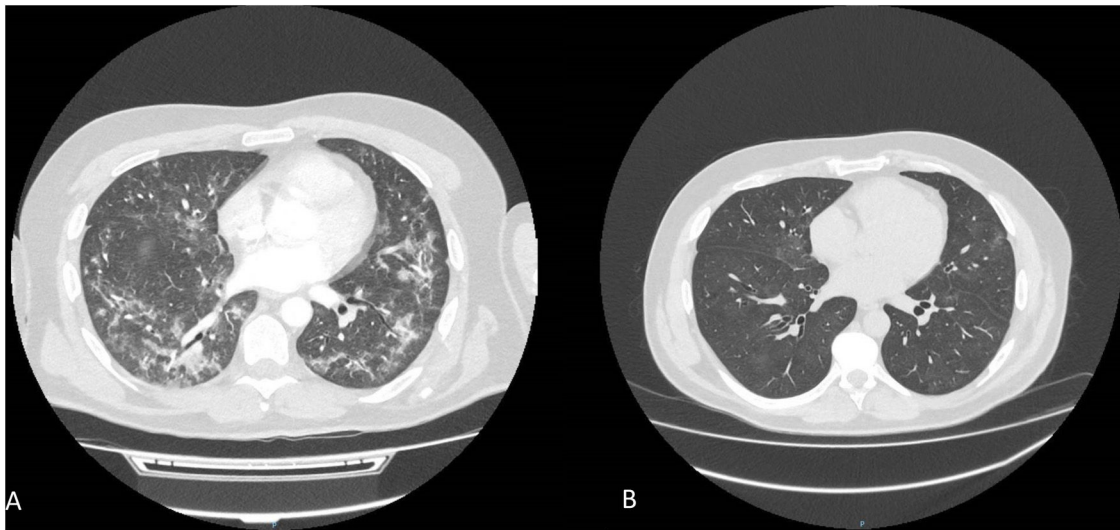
Patient 2. (A) CT scan shows bilateral patchy areas of ground-glass opacities with bronchiectasis at 6 months after started apalutamide. (B) CT scan at 2 months after discontinuing apalutamide, showed practical resolution of the pulmonary signs.
